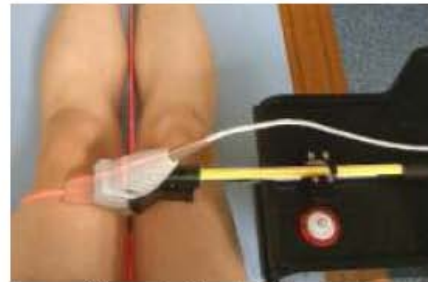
B-mode ultrasound
